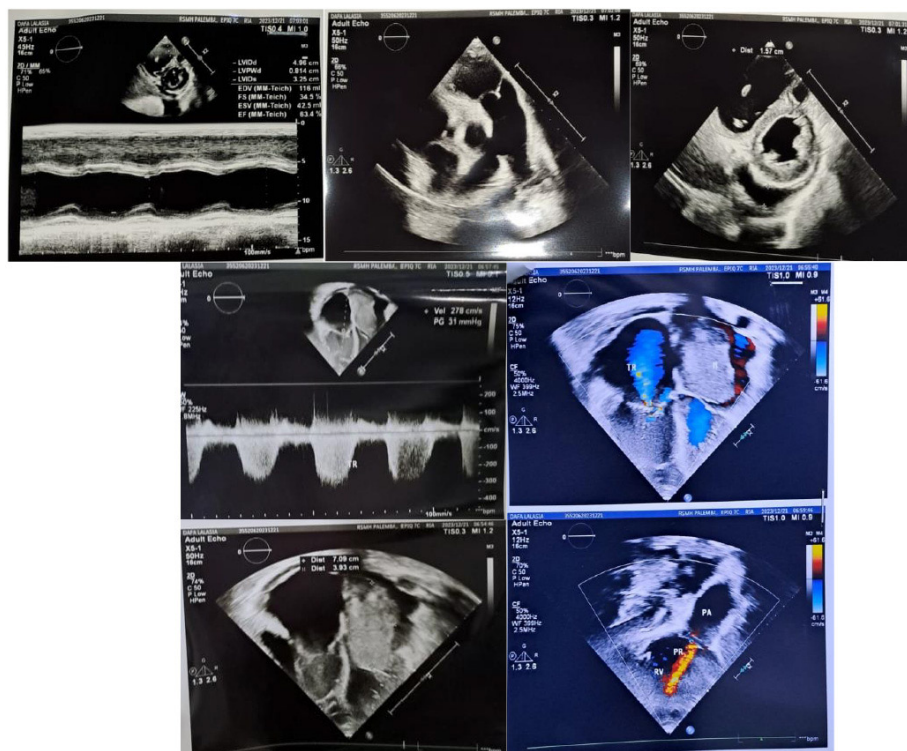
Echocardiography of patient 1
